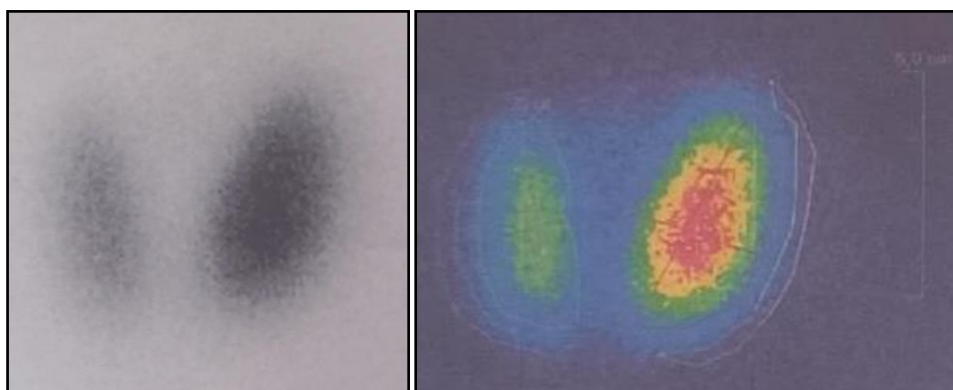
thyroid scintigraphy image of our patient
